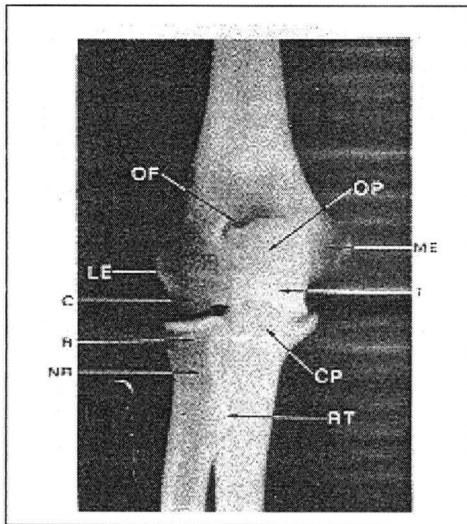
X-ray of the Human Right Elbow Joint (Antero-Posterior view) C, capitulum of humerus; CP, Coronoid Process of ulna; LE, Lateral Epicondyle of humerus; ME, Medial Epicondyle of humerus; OF, Olecranon Fossa of humerus; OP, Olecranon Process of ulna; R, head of Radius; RT, Radial Tuberosity; T, Trochlea of humerus; NR, Neck of the Radial head [2].
